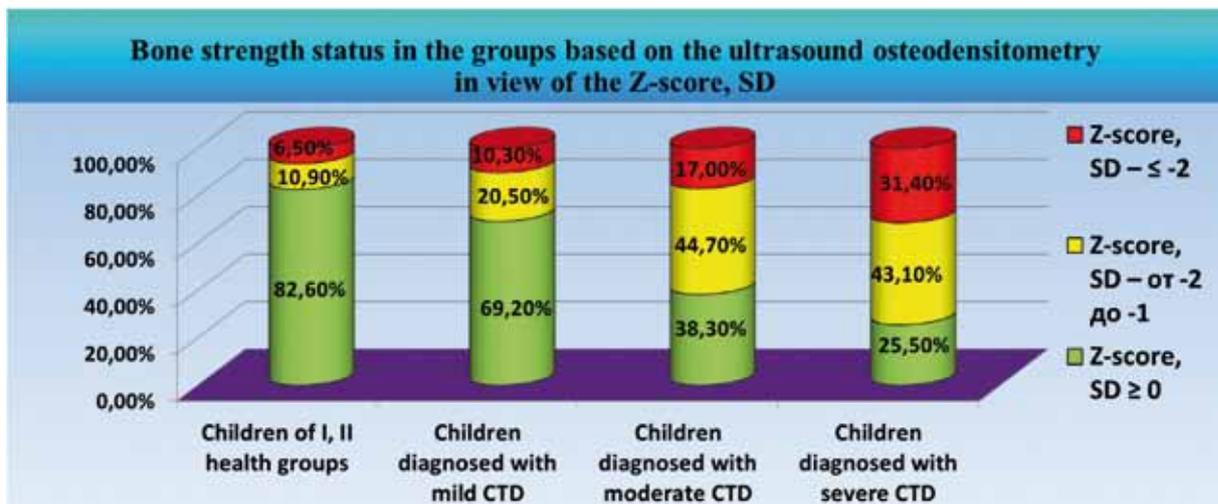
Bone strength status in the groups based on the ultrasound osteodensitometry in view of the Z-score, SD
